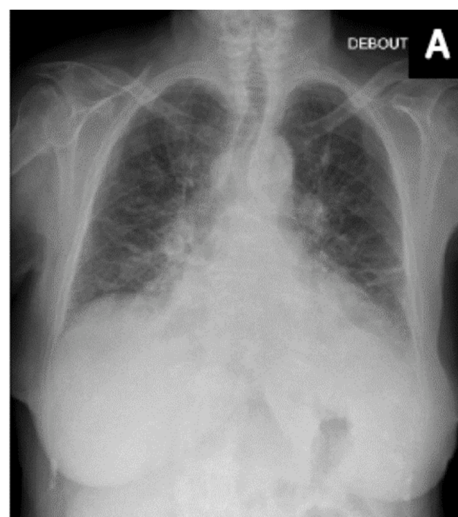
Chest X-ray (A) and CT scan (B) in an 85-year-old patient presenting with a febrile cough. While the X-ray was compatible with the initial diagnosis of bacterial pneumonia, the CT scan corrected the diagnosis to that of left heart failure. Blood and urine cultures confirmed the extra-pulmonary origin of the fever (pyelonephritis with bacteraemia).
